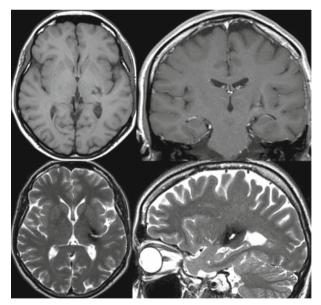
Postoperative triplanar MRI of the same patient showing complete removal of the lesion. There is no reaction as consequence of microsurgical manipulation, neither by the transsylvian approach nor within the perilesional area. Accordingly, there were no additional neurological deficits, and particularly no speech disturbance occurred postoperatively
